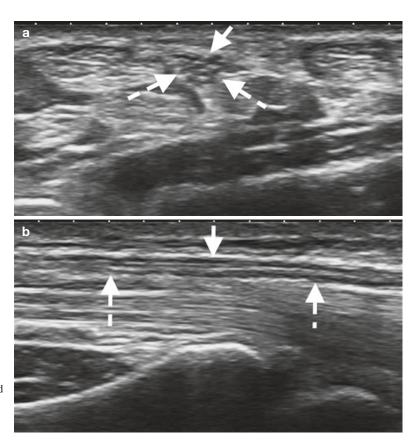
Median nerve (*arrows*) proximal to carpal tunnel: (a) transverse and (b) longitudinal ultrasound images; note the uninterrupted hypoechoic linear bands with intervening linear interrupted hyperechoic bands
